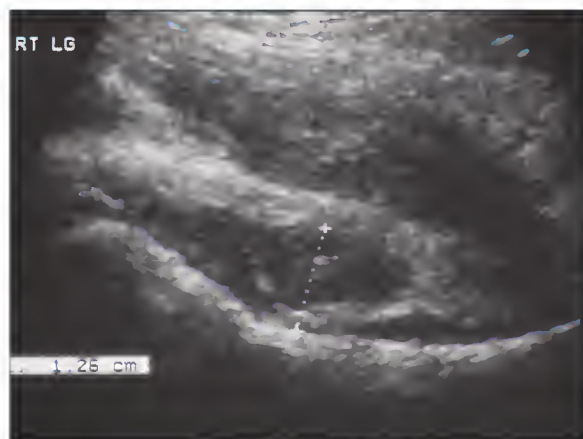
2 Ultrasound image in a patient with irritable hip (transient synovitis of the hip) demonstrating effusion.
